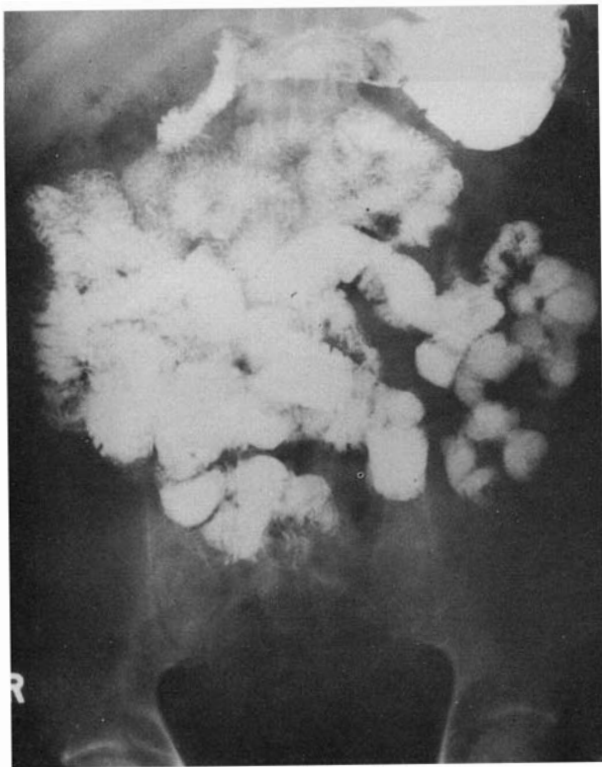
(Case 2.) Barium small bowel X-ray at 15 min. Following more intensive treatment of the leprosy for 18 months, the tracing is now within normal limits. (30 August 1972.)
